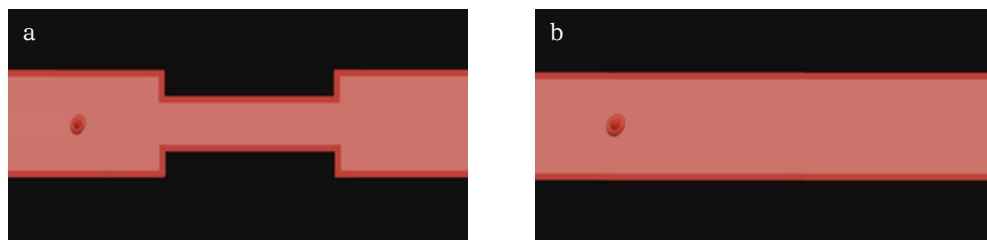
Examples of stimuli presented in the MRI scanner during the blood velocity task: (a) Narrowed blood vessel used in the misconception condition and scientific conditions, (b) Control blood vessel used in the negative control condition and positive control conditions.
